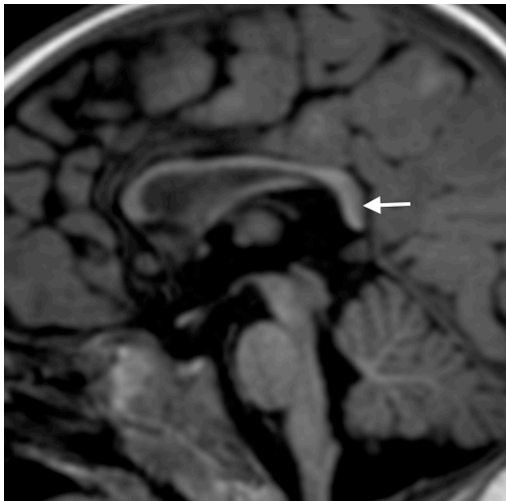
Midline T1 sagittal MRI scan demonstrates a splenium that is circular and bulbous (arrow) in the 6-year-old boy known with transverse myelitis
